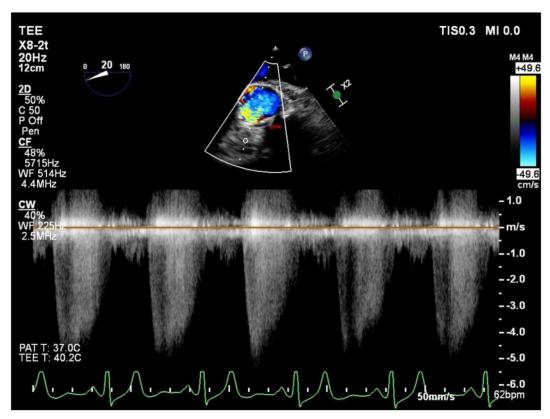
Two-dimensional TEE-guided, continuous-wave Doppler spectrum, midesophageal AV short-axis (20°) view, obtained offaxis due to severe jet eccentricity, demonstrates pressure half-time. Note the peak early AR jet velocity of approximately 4.5 m/sec, suggesting adequate Doppler signal quality.
